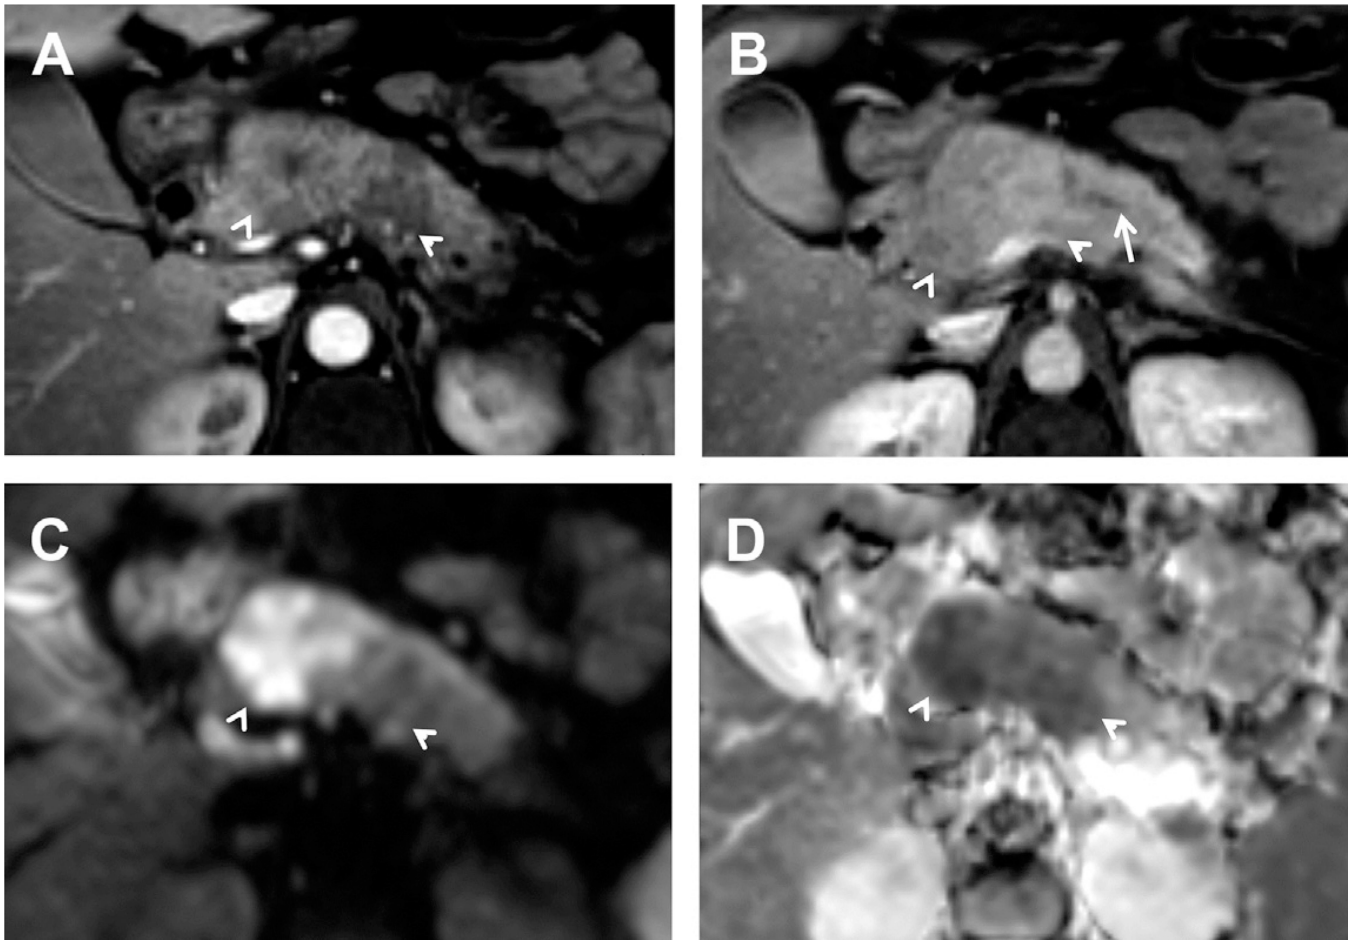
Mass-forming chronic pancreatitis (*arrowheads*). (*A, B*) DCE-MR imaging during the portal and delayed phases show a large mass in the pancreatic head with peripheral enhancement during the portal phase and delayed heterogeneous wash-in. Notice the distal dilatation of main pancreatic duct due to obstruction (*arrow*). (*C, D*) High b-value DWI and corresponding ADC map demonstrate restriction of water motion of the lesion. Notice how the limits of the lesion are better depicted on DWI compared with DCE-MR imaging.
